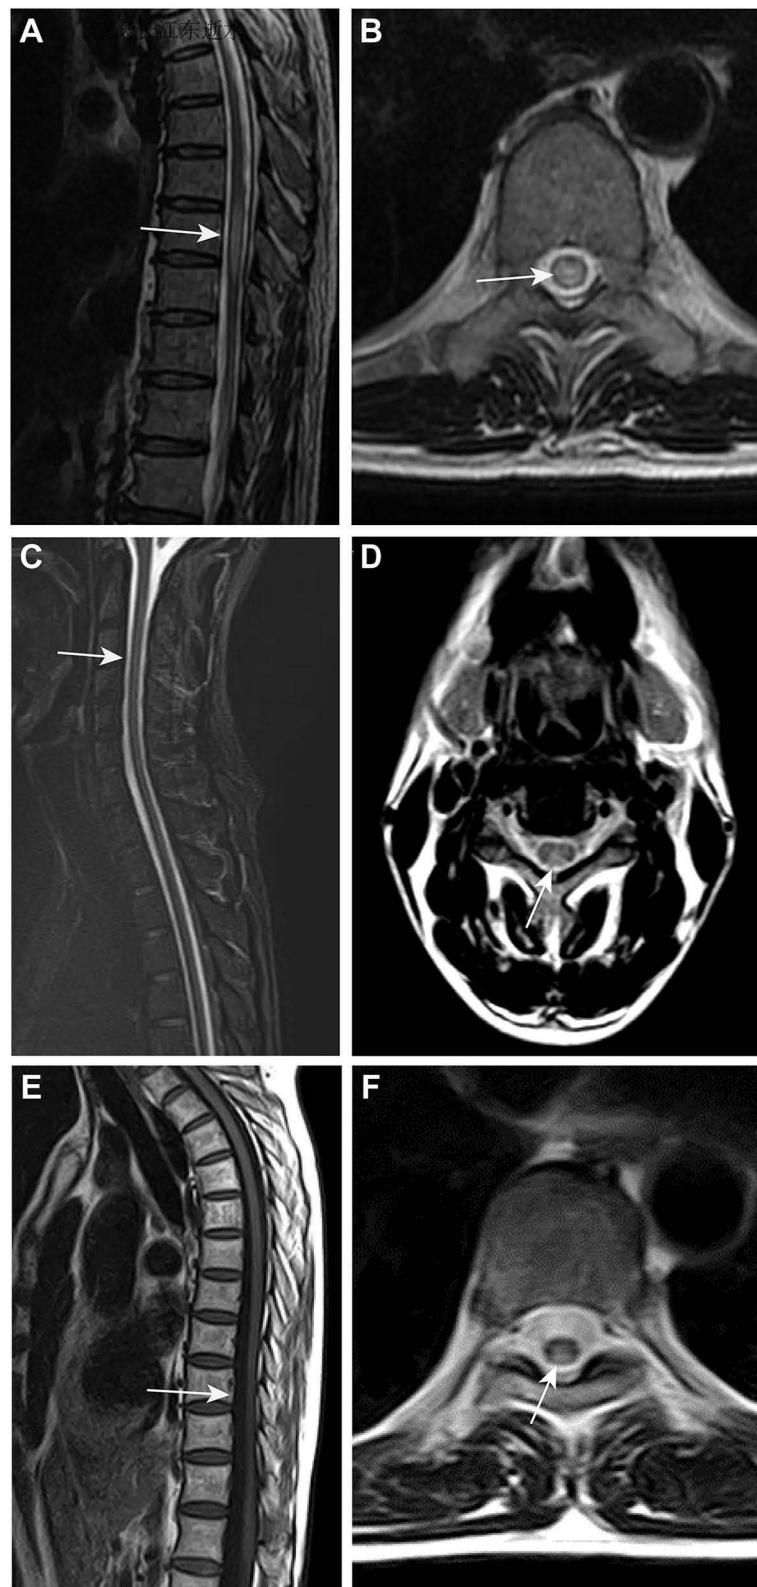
Neuroimaging alterations of tabes dorsalis on spine MRI. (A and B) In a 56-year-old male patient, the sagittal section (A) of T2-weighted image showed intramedullary hyperintensity from T8 to T10 (arrow). The axial section (B) of T2-weighted image at the T9 level showed the lesion affecting nearly the entire cross-section of the spinal cord without associated expansion (arrow). (C and D) In a 34-year-old male patient, the sagittal section (C) of T2-weighted image showed intramedullary hyperintensity in the cervical and upper thoracic spine (arrow). The axial T2-weighted image (D) at the T2/3 level showed the lesions mainly affecting the dorsal columns (arrow). (E and F) In a 58-year-old female patient, the sagittal section (E) of T1-weighted image showed spinal cord atrophy at the lower thoracic level (arrow). The axial T2-weighted image (F) at the T8 level showed intramedullary hyperintensity in the dorsal spinal cord (arrow).
